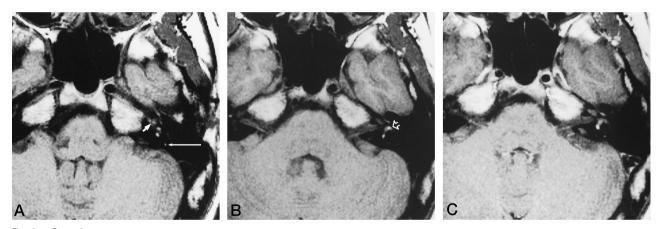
Case 2. A–C, Axial T1-weighted images (522/20/2) before (A and B) and after (C) contrast administration show increased signal attributed to hemorrhage in the cochlea (short arrow), vestibule (open arrow), and posterior crus (long arrow) on the left. No contrast enhancement has occurred.
